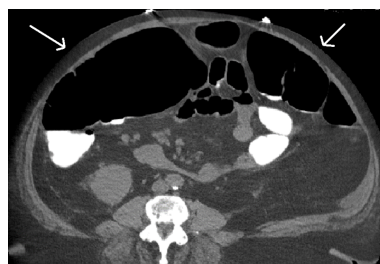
Abdominal CT scan axial image with gaseous distension of cecum and colon (arrows). Contrast is seen in colon.
